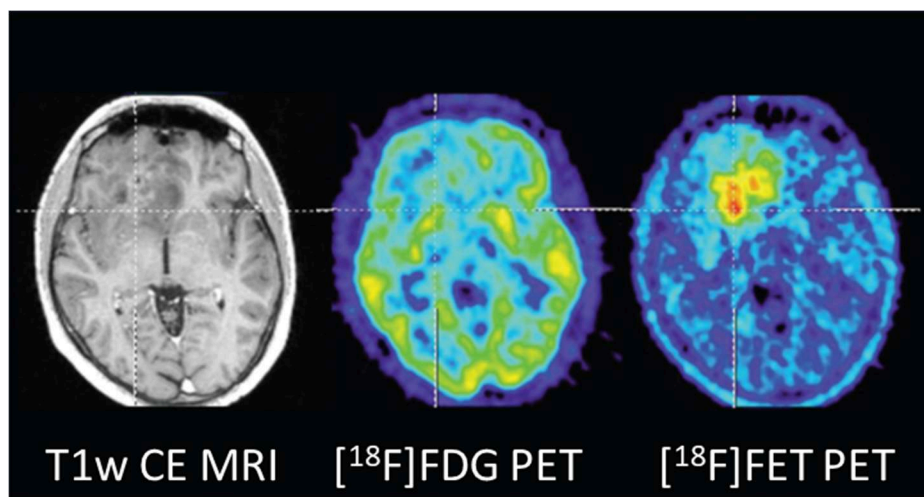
Comparison of MRI, FDG, and FET PET in a patient with a non-enhancing anaplastic astrocytoma. While the tumour does not show contrast enhancement (CE) on the T1-weighted MRI (left) or an increased uptake of FDG (centre), a metabolically active tumour was revealed by FET PET (right). Image adapted from Galdiks et al. [72].
